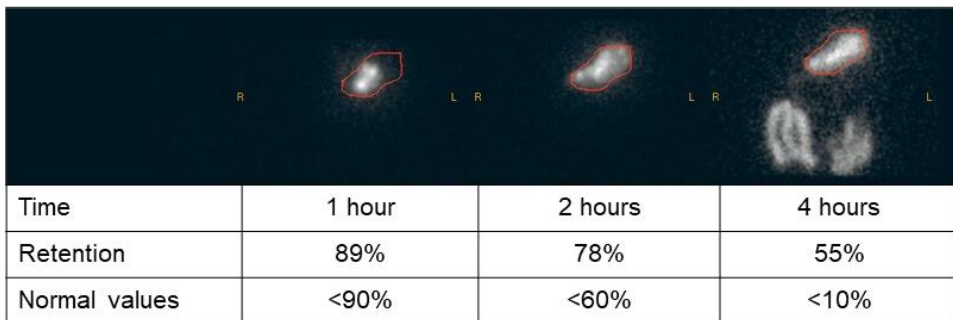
Gastric emptying scintigraphy results in the same patient as in Figure 13. More than half of the radioisotope meal is left in the stomach after four hours, indicating severe gastric retention. Figure by Sangnes et al. *Tidsskr Nor Laegeforen*. 2016, adapted and reprinted with permission [143].
